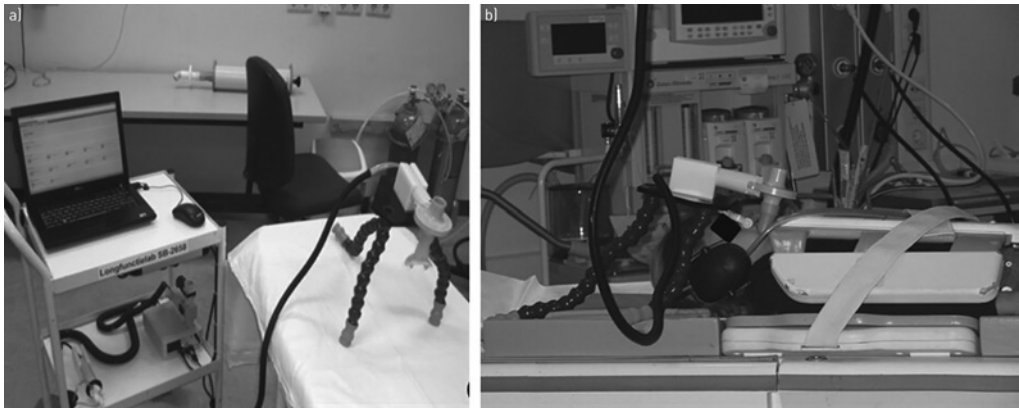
Magnetic resonance imaging (MRI) spirometer set-up. (a) Metal-free plastic tripod, mouthpiece and the MRI compatible spirometer in the lung function room where the breathing manoeuvres were trained. (b) In the MRI suite, the spirometer is connected to the computer by long plastic tubing, which is introduced into the Faraday cage, to measure differential pressure for computation of flow.
